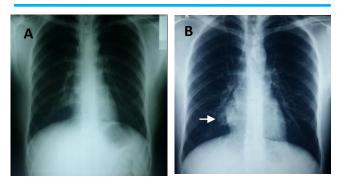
(A) Chest radiograph done in 2015 as part of the patient's annual physical examination signed out as a normal study. (B) Chest radiograph done in 2016 showing a well-circumscribed nodular opacity in the right parahilar region demonstrating the hilum overlay sign.
